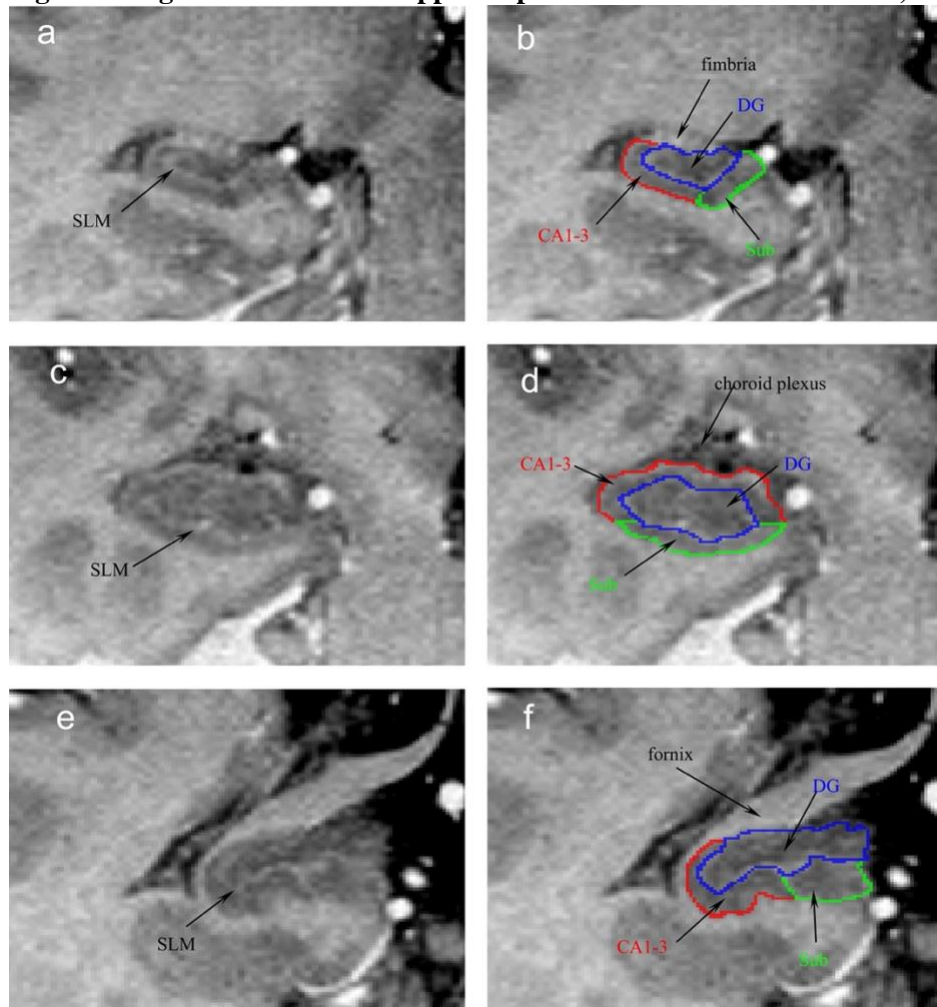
Figure originally printed in Travis et al., 2014. Segmentation of the hippocampus (HC) subfields within HC sub-regions is shown on T2-weighted Fast Spin Echo (FSE) images using inverted contrast: coronal views of the hippocampal body (a and b); hippocampal head (c and d); hippocampal tail (e and f). Abbreviations: CA1–3=cornu ammonis (shown in red); DG=dentate gyrus (shown in blue); sub=subiculum (shown in green); SLM=stratum lacunosum-moleculare
